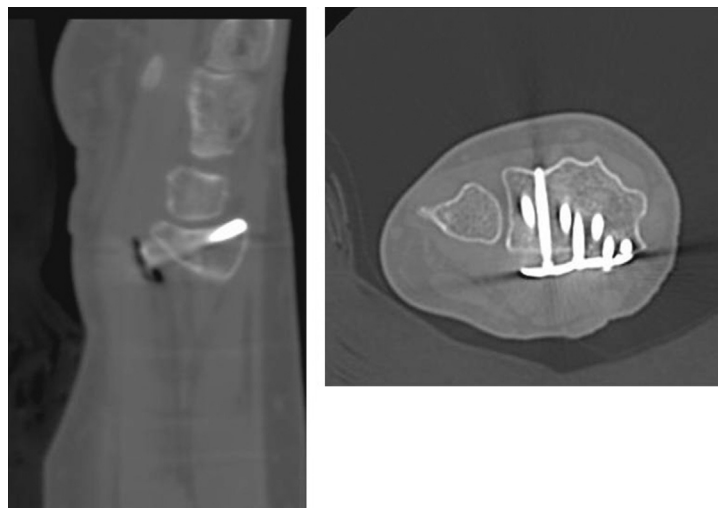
Images from the CT study compared with Rx using supports. It is possible to confirm the slight dorsal protrusion observed in Fig. 2.
